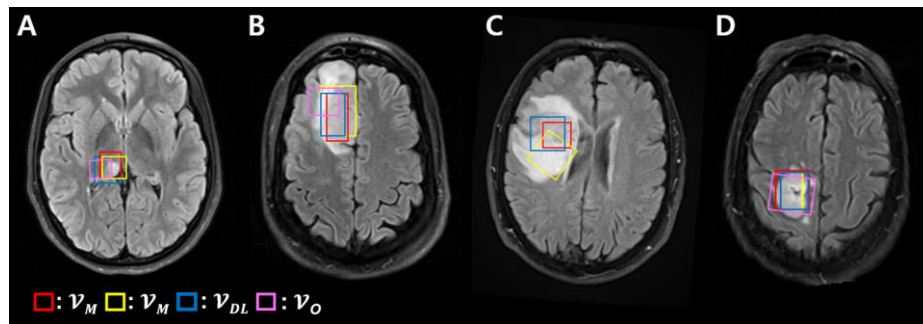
Comparisons of \mathcal{V}_M (red and yellow), \mathcal{V}_{DL} (blue) and \mathcal{V}_O (pink) overlaid on T_2w -FLAIR images. Note in (C) the objective function-based placement (\mathcal{V}_O) is in a different region of the tumor and does not intersect the selected plane.
